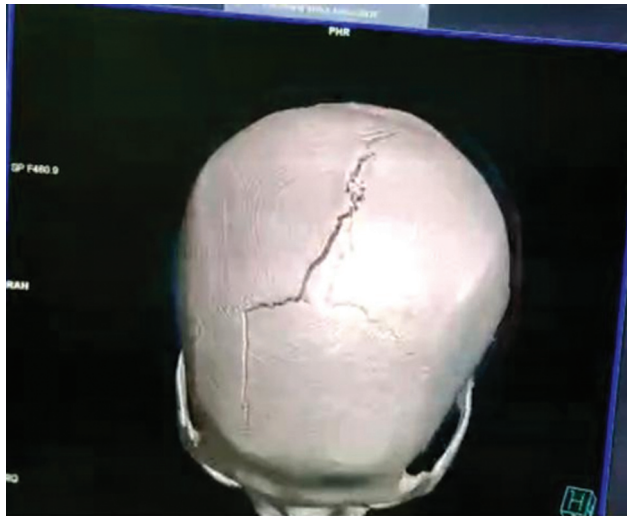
Computed tomography head showing fracture over vault of skull along with diastasis of sagittal suture.
